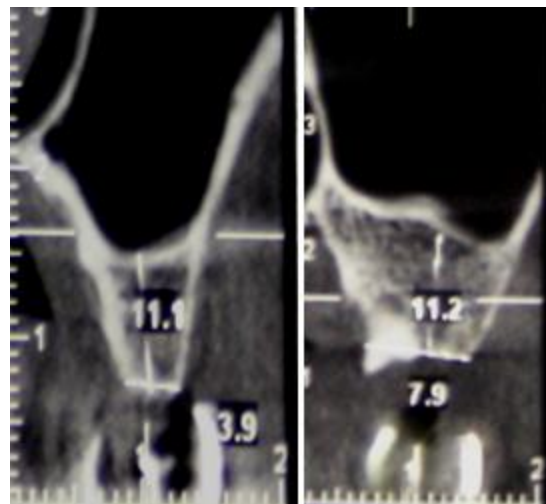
Cone-beam computed tomographic (CBCT) analysis before implant placement
